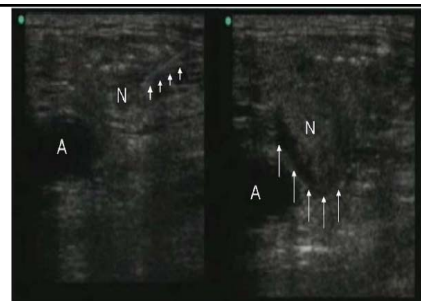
Ultrasound images of the femoral nerve block. Left, Before anesthetic injection: artery (A), nerve (N), and needle (indicated by short white arrows). Right, After anesthetic injection: artery (A), nerve (N), with anesthetic surrounding the nerve (outlined by long white arrows).
